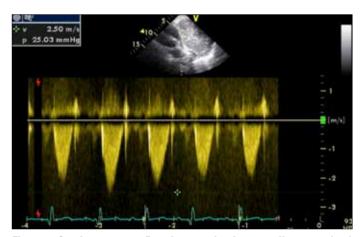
Continuous wave Doppler examination revealing a maximal 25 mmHg of transpulmonary gradient due to the tumoral compression
